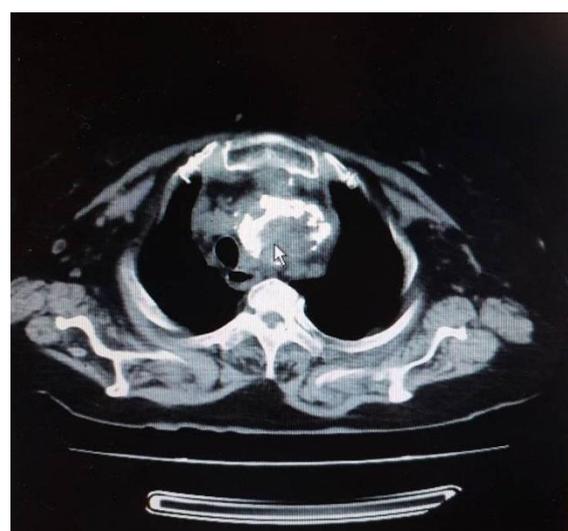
The CT scan on the right shows an enlarged left thyroid lobe displacing and narrowing the trachea behind the sternal notch. Lung Parenchyma was normal.
